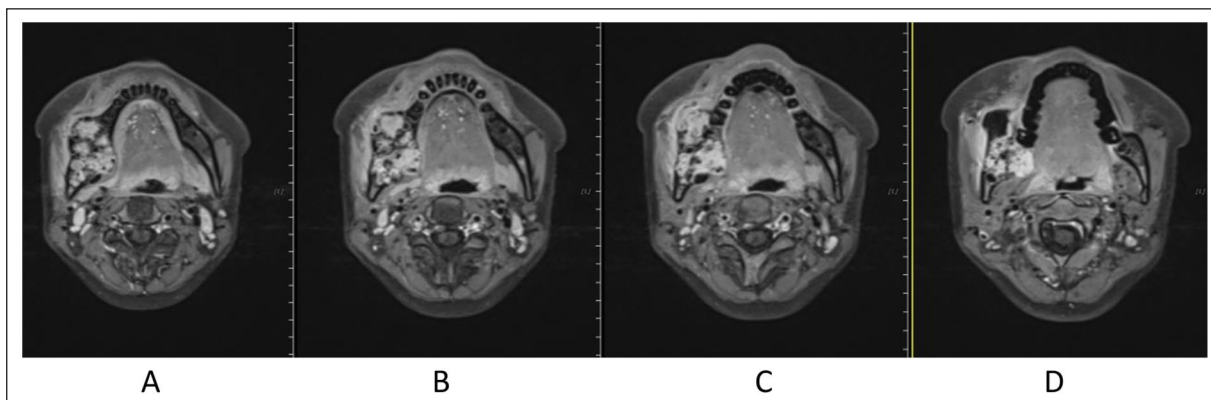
Before CIRT (2020-04) different slices of Contrast-enhanced MR T1: A. Contrast-enhanced MR T1, B. Contrast-enhanced MRI, TWII, C. Contrast-enhanced MR T1, D. Contrast-enhanced MR T1
